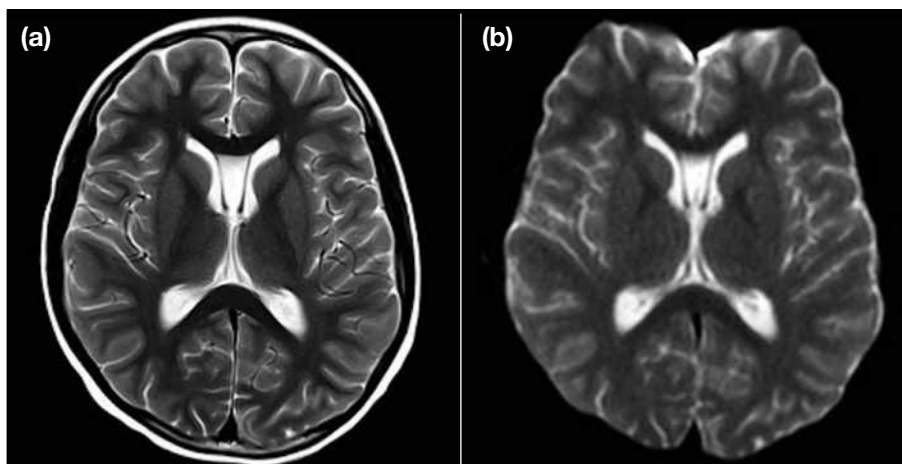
Follow-up magnetic resonance imaging in case 1 after 6 months of presentation. There is resolution of thalamic signal abnormalities on both (a) T2-weighted and (b) diffusion-weighted imaging sequences.
